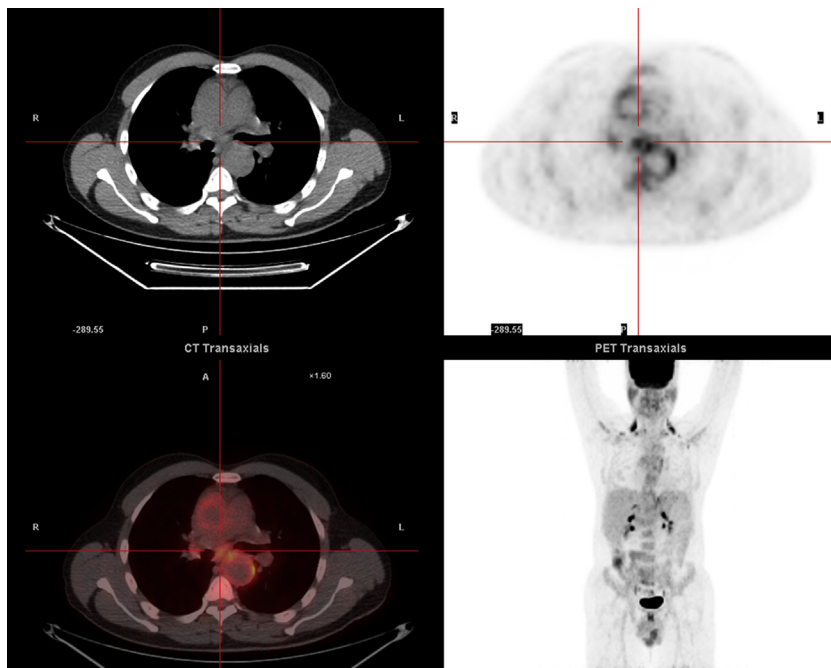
Aortitis in patients with Takayasu's arteritis. Positron emission tomography—computed tomography: hypermetabolic activity and enlargement of the thoracic aorta in a patient with Takayasu's arteritis.
